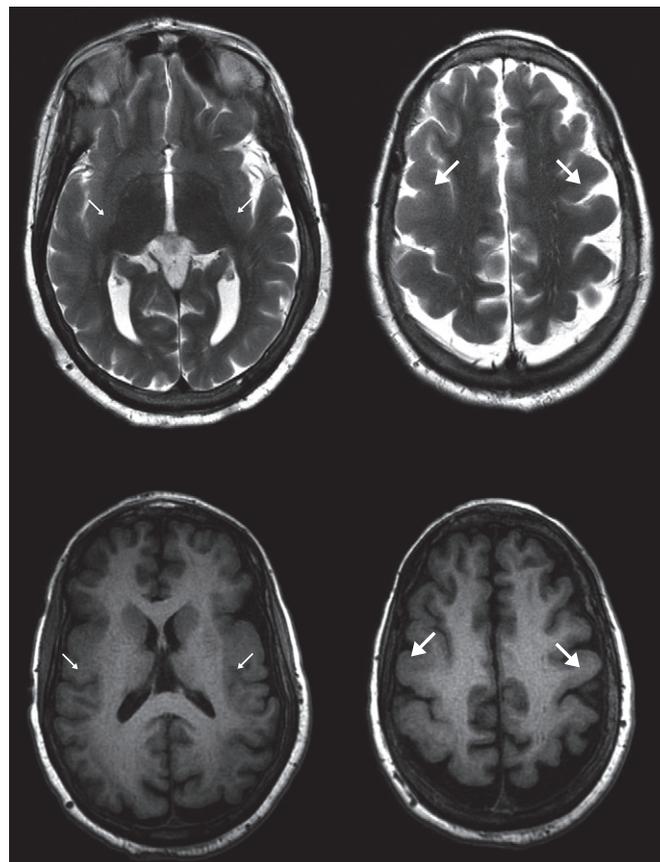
Axial T2-weighted (top two slices) and T1-weighted (bottom two slices) MRI of the head shows bilateral cortical dysplasia with fairly symmetric thickening in both frontal lobes (large arrows), involving the middle and inferior frontal gyri particularly with some extension to the precentral gyri. There is cortical thickening seen in the parietal lobes and upper insula posteriorly (small arrows).
